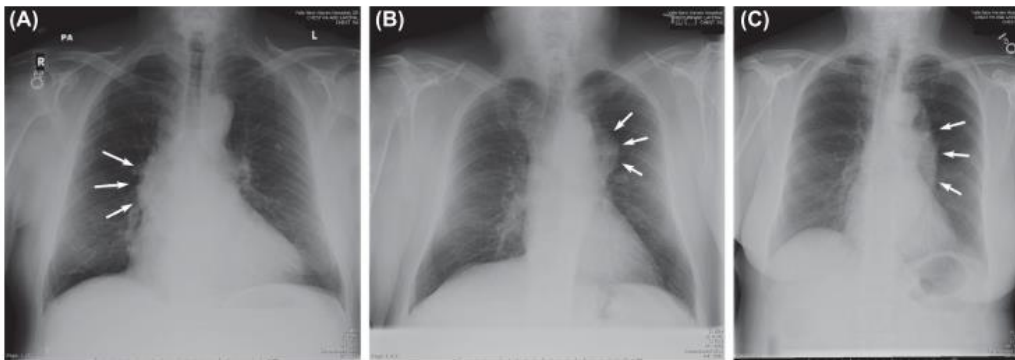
TAAs diagnosed by chest plain X-rays. (A) Ascending; (B) Arch; (C) Descending. (Reproduced from Damberg *et al.*⁵² with permission from Elsevier)
